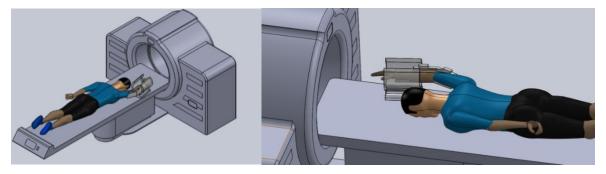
CAD model of design in MRI setting (left: top view, right: side view)
